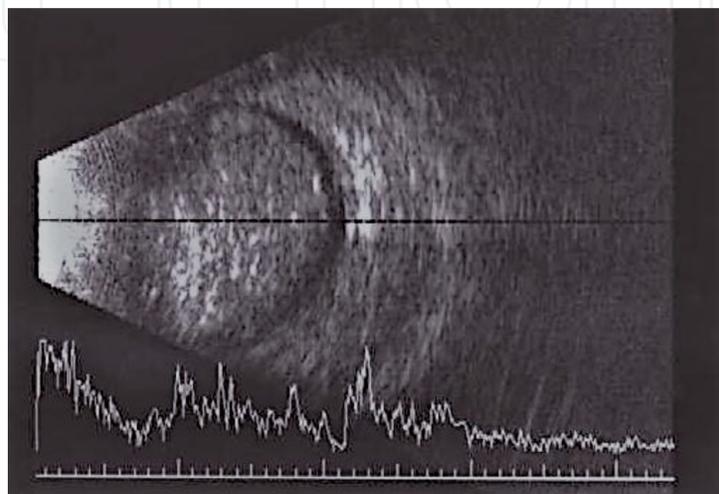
10 mHz ultrasound in A and B scan mode showing a large intraocular retinoblastoma with irregular mass and intrinsic calcification with acoustic shadowing.
